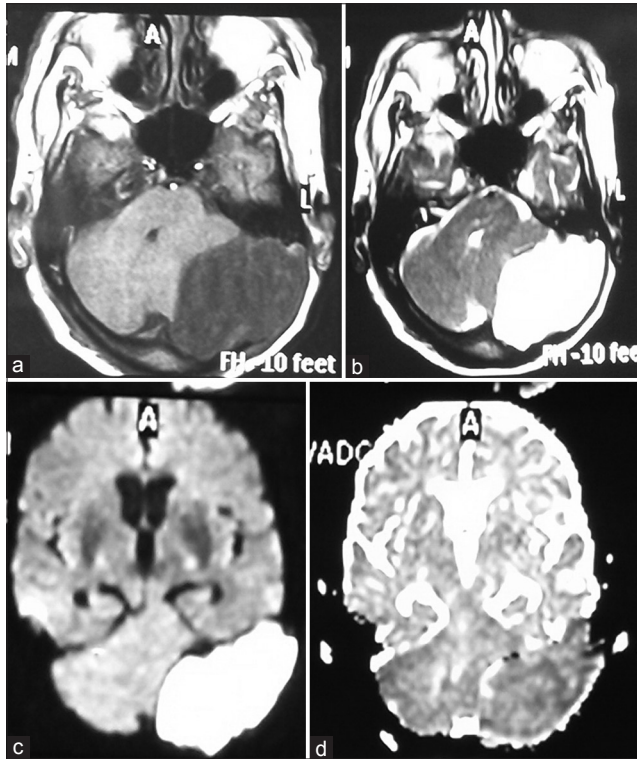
The first brain magnetic resonance imaging performed for the patient revealed an extradural posterior fossa mass lesion that was hypointense in T1 (a) and hyperintense in T2, (b) increased signal intensity in diffusion-weighted imaging, (c) and decreased signal intensity in apparent diffusion coefficient map, (d) suggested the diagnosis of an epidermoid tumor
